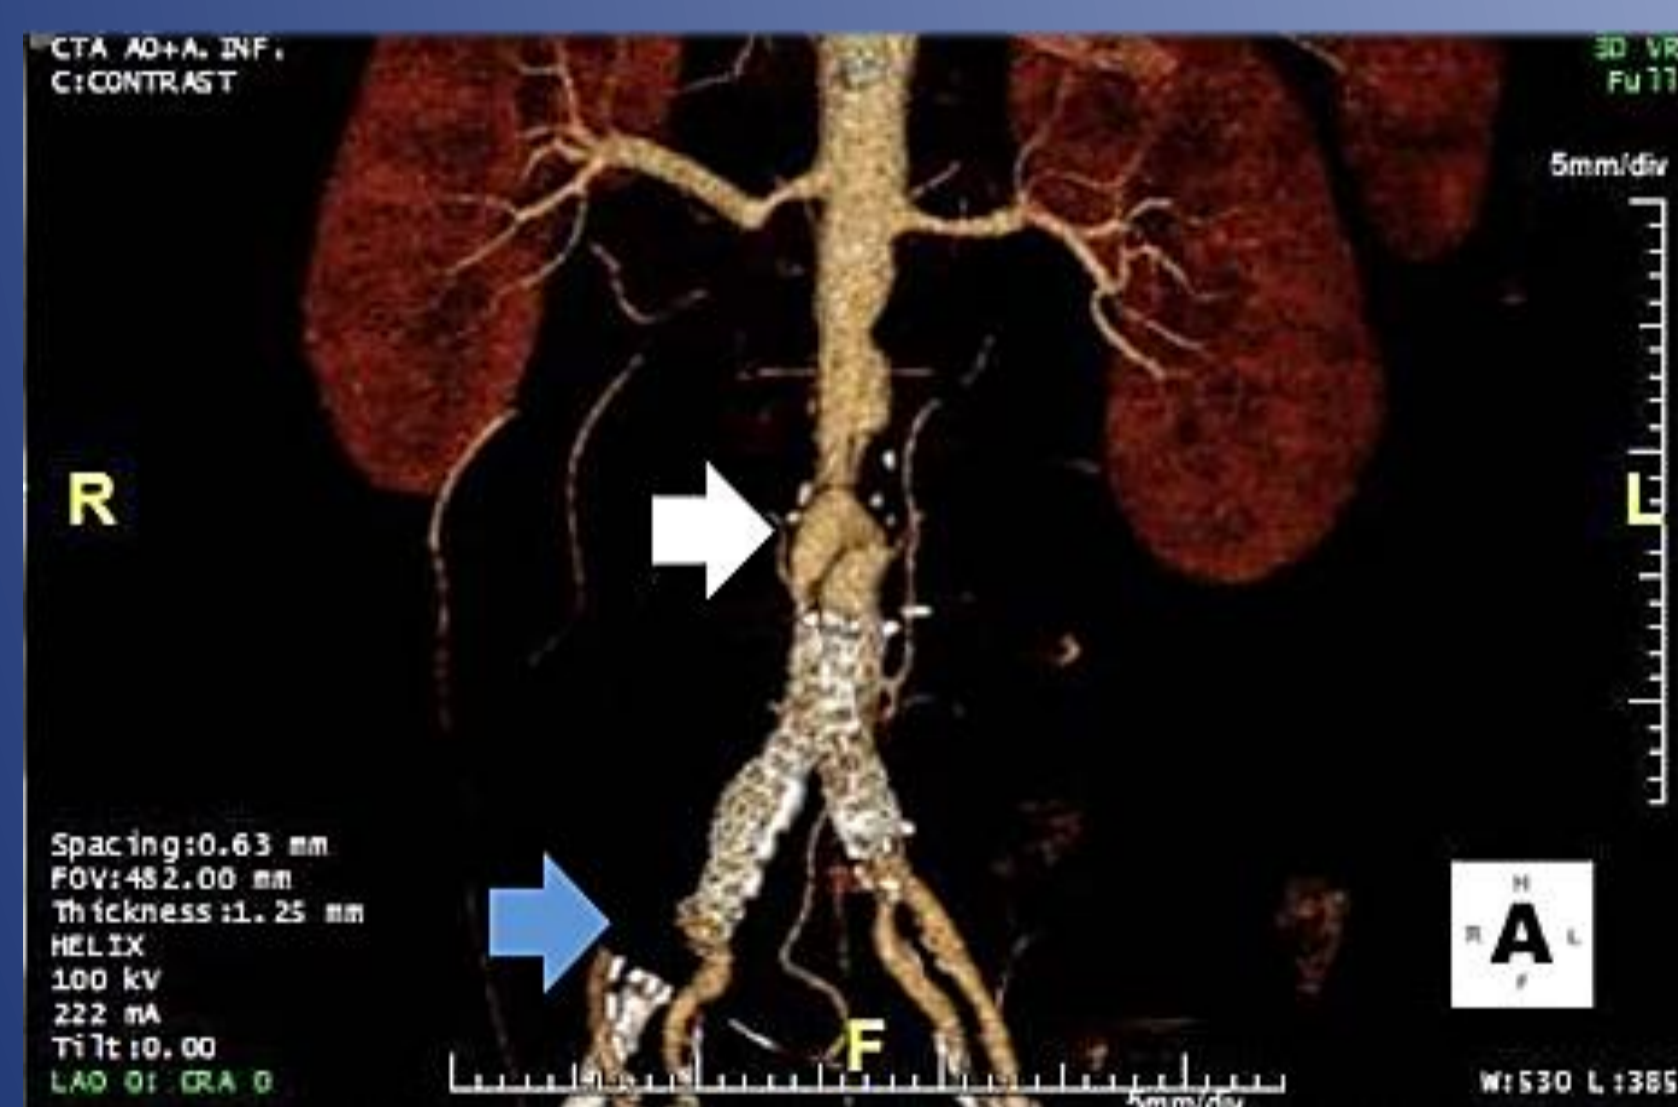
Post-operative CTA (1 year) with 3D volume-rendering (right box). Regular placement of all deployed endografts. The Gore Excluder IBE is placed at the infrarenal position and the Gore Viabahn endoprosthesis is well conformed within the infrarenal aorta. The IIA is patent on both sides.
